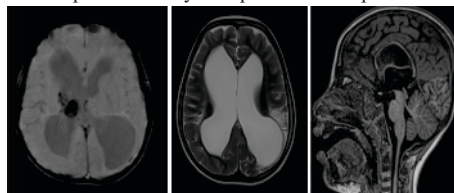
MRI axial SWI and T2 axial and sagittal Chronic haemorrhage in right thalamus, Hydrocephalus with volume loss and gliotic changes, thinning of corpus callosum.
